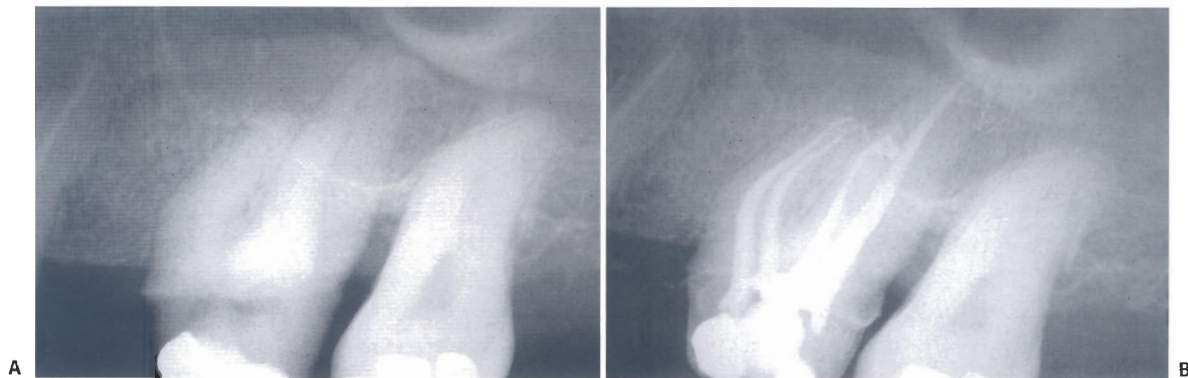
Clinical cases of teeth with canals having moderate curvatures. A. Preoperative radiograph of the upper left first molar. B. Postoperative radiograph (E. Berutti) (continued).
